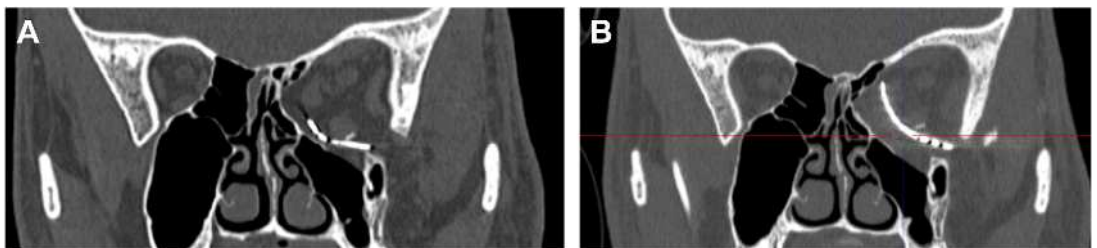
(A) Preoperative coronal CT image demonstrating increase in intraorbital volume and suboptimal correction of floor and medial wall fractures of the left eye. Image also shows implant placed improperly. (B) Revised reconstruction of the left orbit using personalized titanium implant demonstrating improved radiological outcomes.
